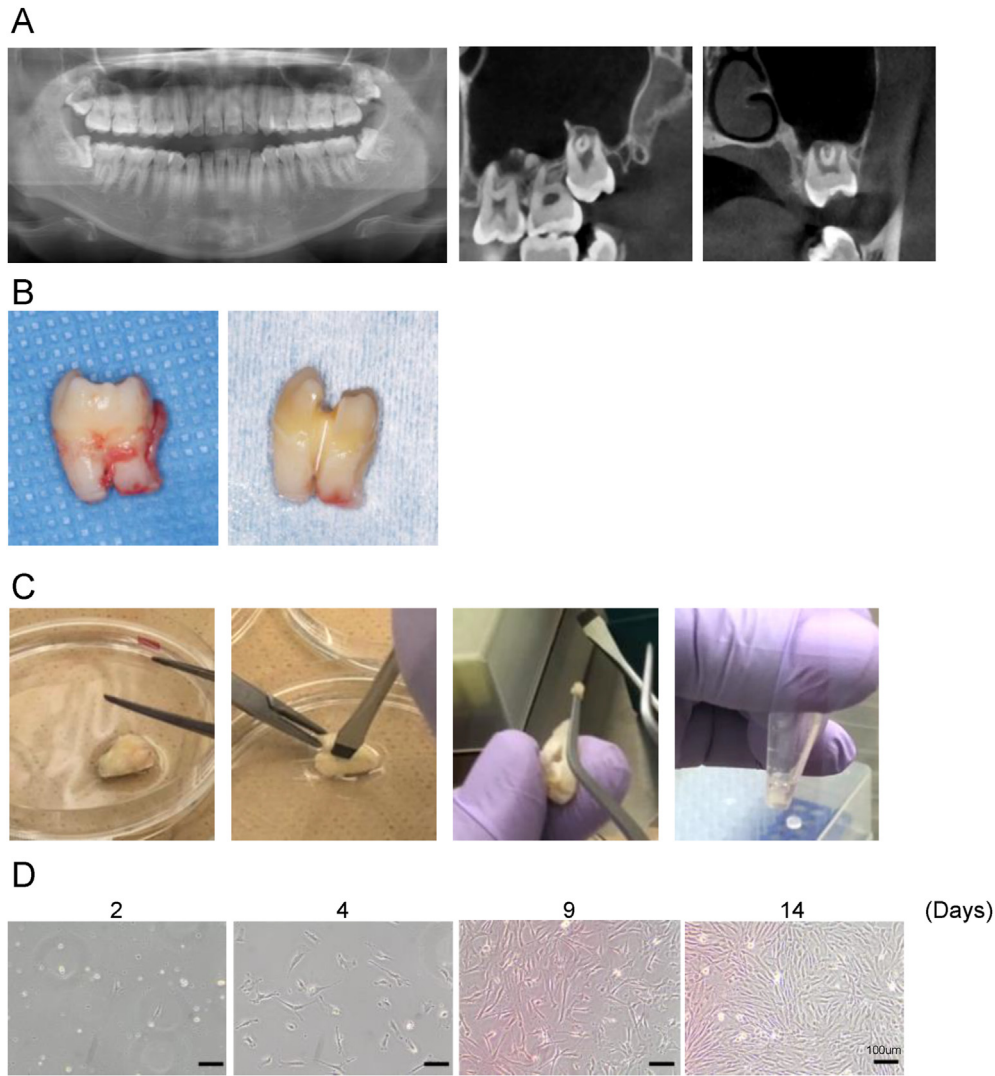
hDPSC Isolation and Culture. (A) Panoramic radiograph and Sagittal and coronal plane image of corn beam computed tomography (CBCT) images of impacted wisdom teeth. (B) Extracted wisdom tooth with removed periodontal ligament, sectioned. (C) Dental pulp isolated for hDPSC isolation using enzyme digestion. (D) Primary hDPSCs reaching subconfluence after 10–14 days in culture.
